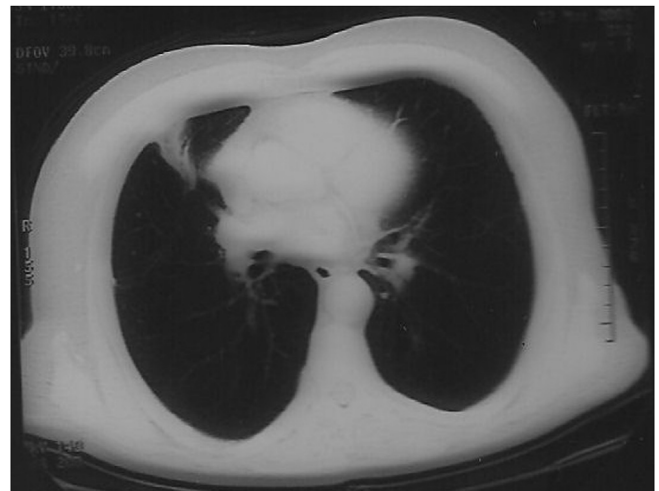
Patient thorax CT after Chemotherapy [1].
